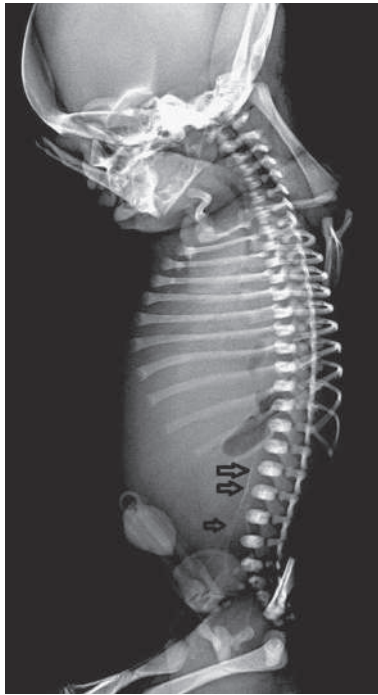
Lateral radiograph of the neonate showing calcification of the descending aorta and its bifurcation (arrows). (From Karthikeyan G. Generalized arterial calcification of infancy. *J Pediatr.* 2013;162:1074, Fig 3.)
